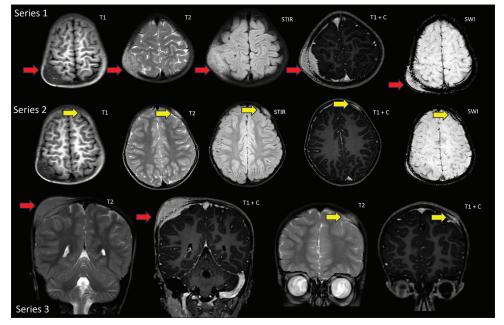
Sequential axial and coronal T1, T2, short tau inversion recovery, postcontrast T1 weighted, and susceptibility weighted image weighted magnetic resonance imaging images show multiple enhancing lesions in the skull (red arrow in Series 1 and 3) and (yellow arrow in Series 2 and 3). STIR: Short tau inversion recovery, SWI: Susceptibility weighted images, MRI: Magnetic resonance imaging
